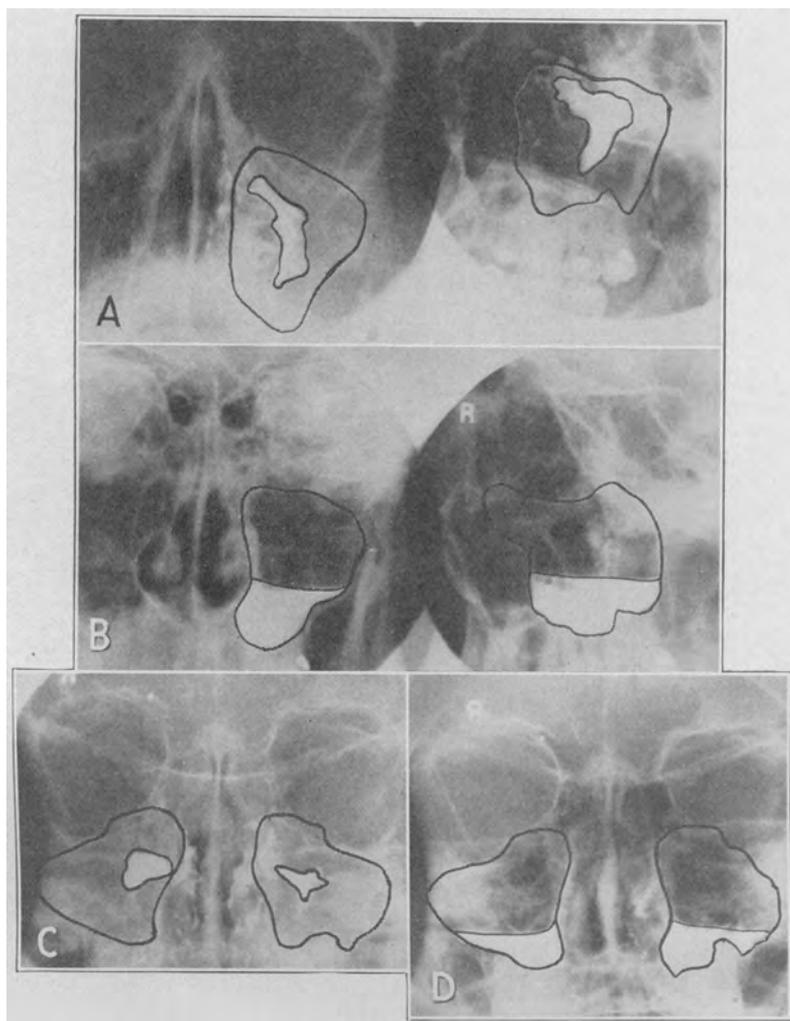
A man aged 28 had a cold for ten days and discomfort over the right antrum for six days. Note the marked filling defect in the right antrum (*A*). There was immediate improvement, and no further treatment was given for nine days, when a second injection and roentgenogram were made (*B*), showing that one injection of oil was sufficient to clear the sinus.
